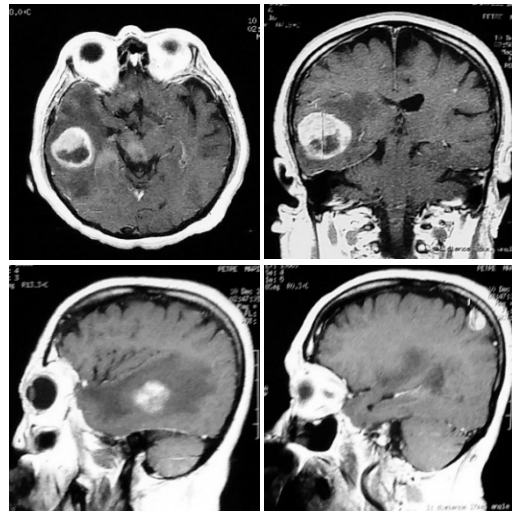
MRI aspect of intratumoral hemorrhage (brain metastases from malignant melanoma)
